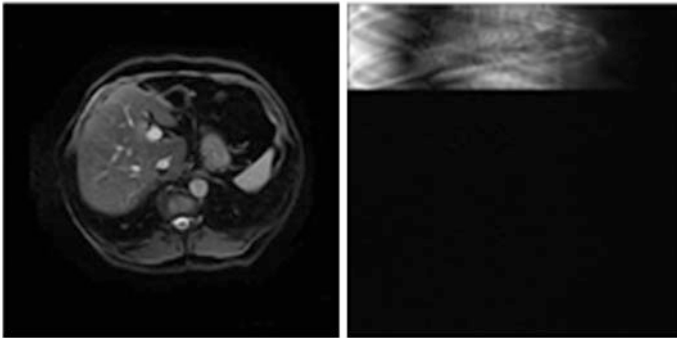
A liver MR image (left) and Rip-II ($d = 3$, level = 2) coefficients (right) of this image
